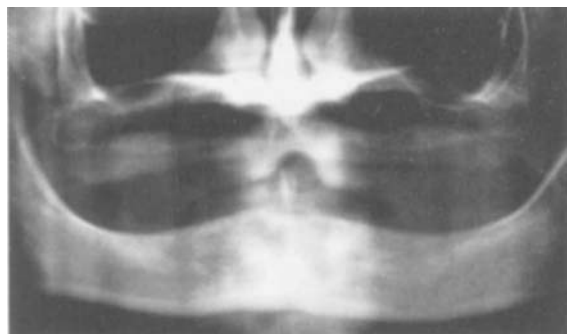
■ Preoperative radiograph of available bone.
